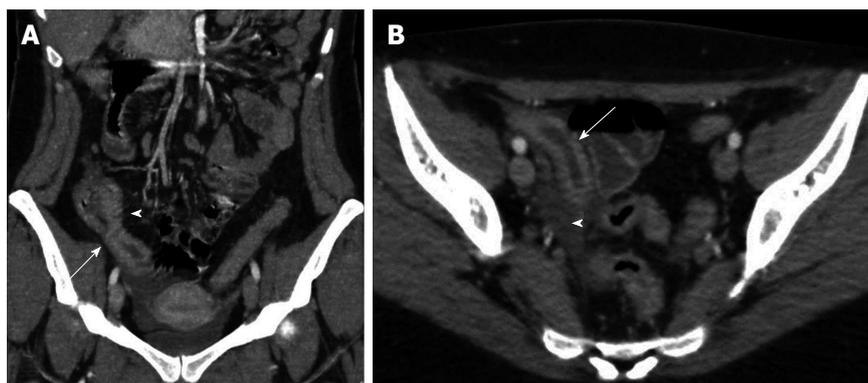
Crohn's disease. A: Computed tomography (CT) coronal reconstruction shows terminal ileal loop thickening with white attenuation pattern (arrow) and perivisceral vasa recta (arrowhead); B: Transverse CT scan shows thickening of the terminal ileal loop (arrow) associated with perivisceral endoperitoneal fluid (arrowhead).
